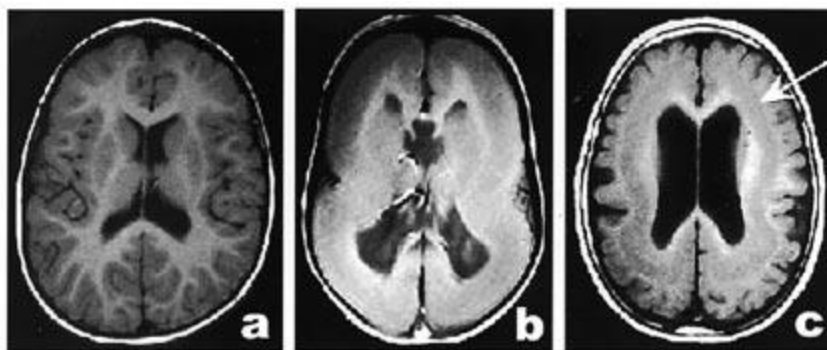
T1-weighted magnetic resonance images of a healthy brain compared with two Lissencephaly patient brains. (a) A healthy brain; (b) Classical Lissencephaly with a mutation in DCX gene (c) SBH in a female child with a mutation in DCX gene, the arrow indicates the subcortical band. Picture adapted from reference [96].
